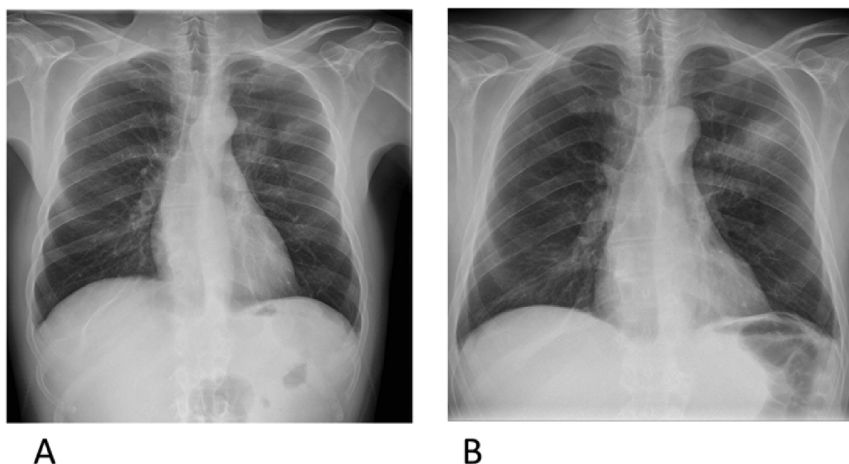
Comparison between chest radiograph images at the time of first admission (A) and at the time of the second admission after completion of the antibiotic cycle (B).
